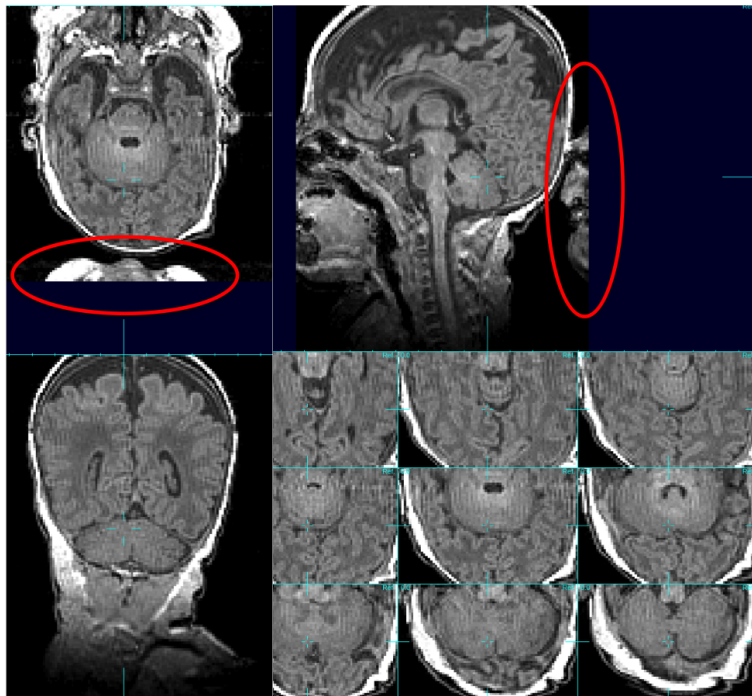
An example of wrap-around artifact from Vancouver dataset. The face of the subjects is wrapping posterior to the back of the head in MRI.
